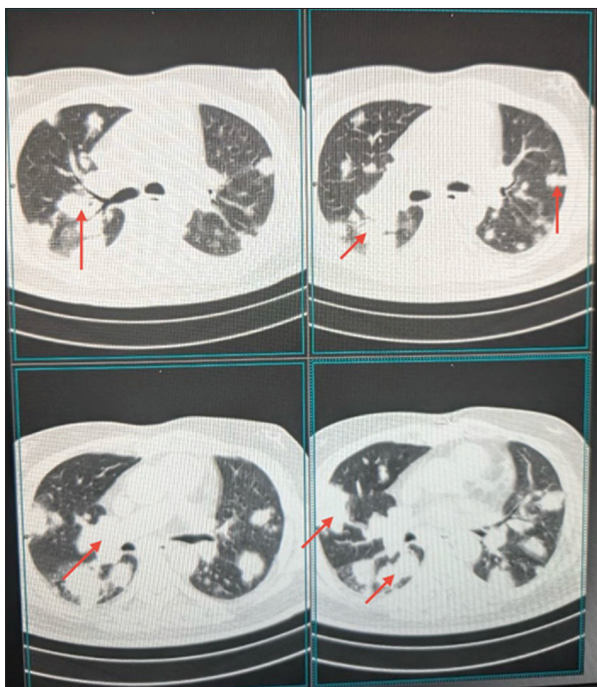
Contrast-enhanced computed tomography demonstrating bilateral nodular opacities suggestive of metastatic malignancy
